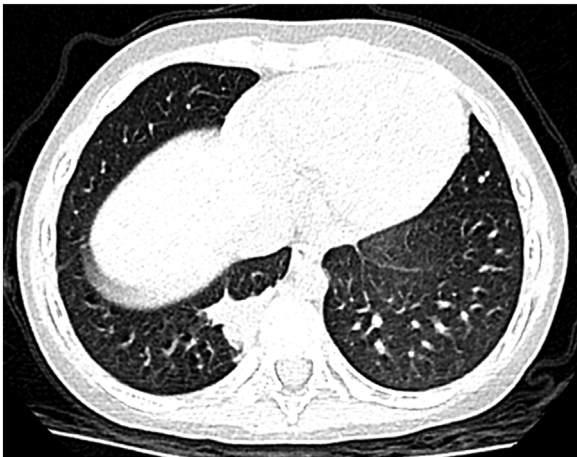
The chest CT scan of patient after antimicrobial therapy for four months. Examination of the chest CT scan of patient showed significant reduction of lung lesions after antimicrobial treatment for 4 months.
